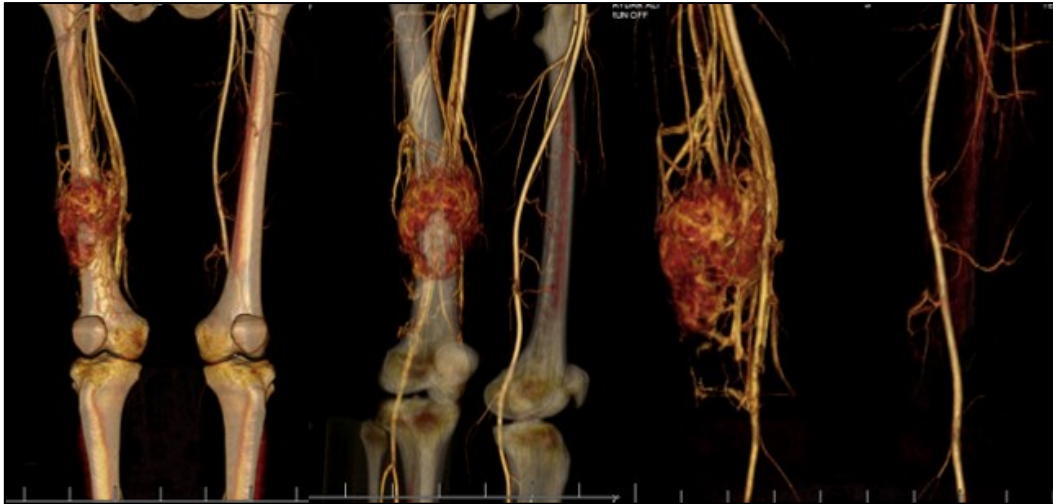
Preoperative (CT-3D) Angiography
